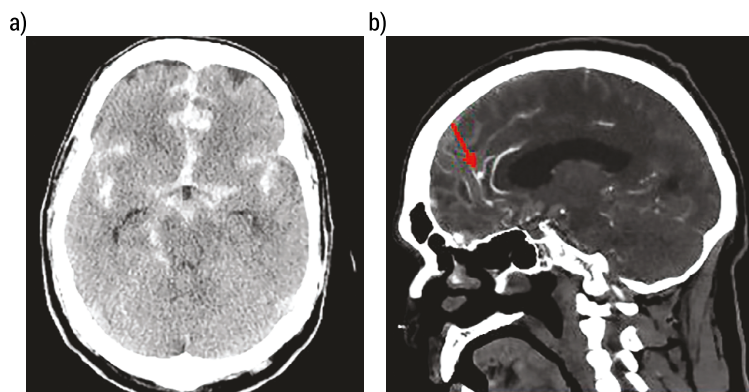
Head CT (A) demonstrates angioCT (B) showing a 5-mm ruptured aneurysm (arrow) [45]
